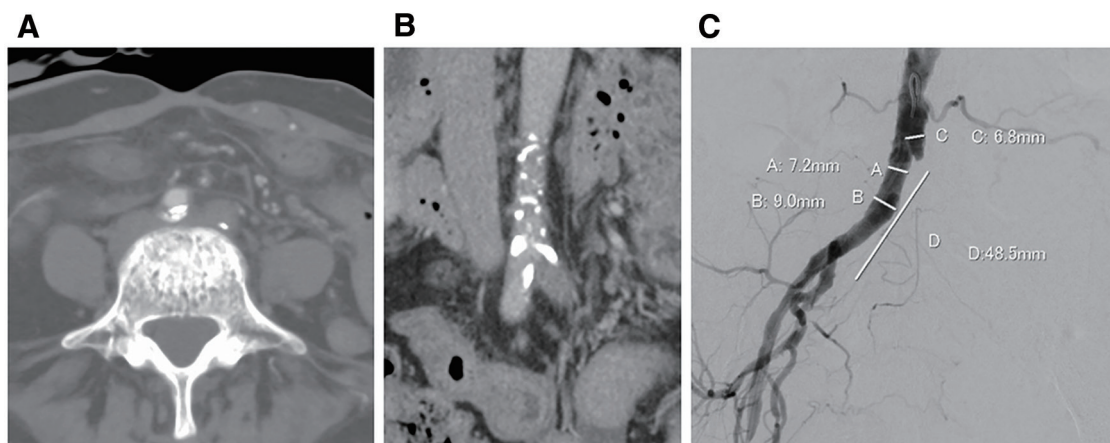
(A) CT revealed chronic total occlusion of the left iliac artery from the common iliac artery to the beginning of the external artery. (B) CT shows the aortic diameter was narrow, and mural calcification was present in the right common iliac artery. (C) The angiography shows the aortic diameter was narrow. CT: contrast-enhanced computed tomography
